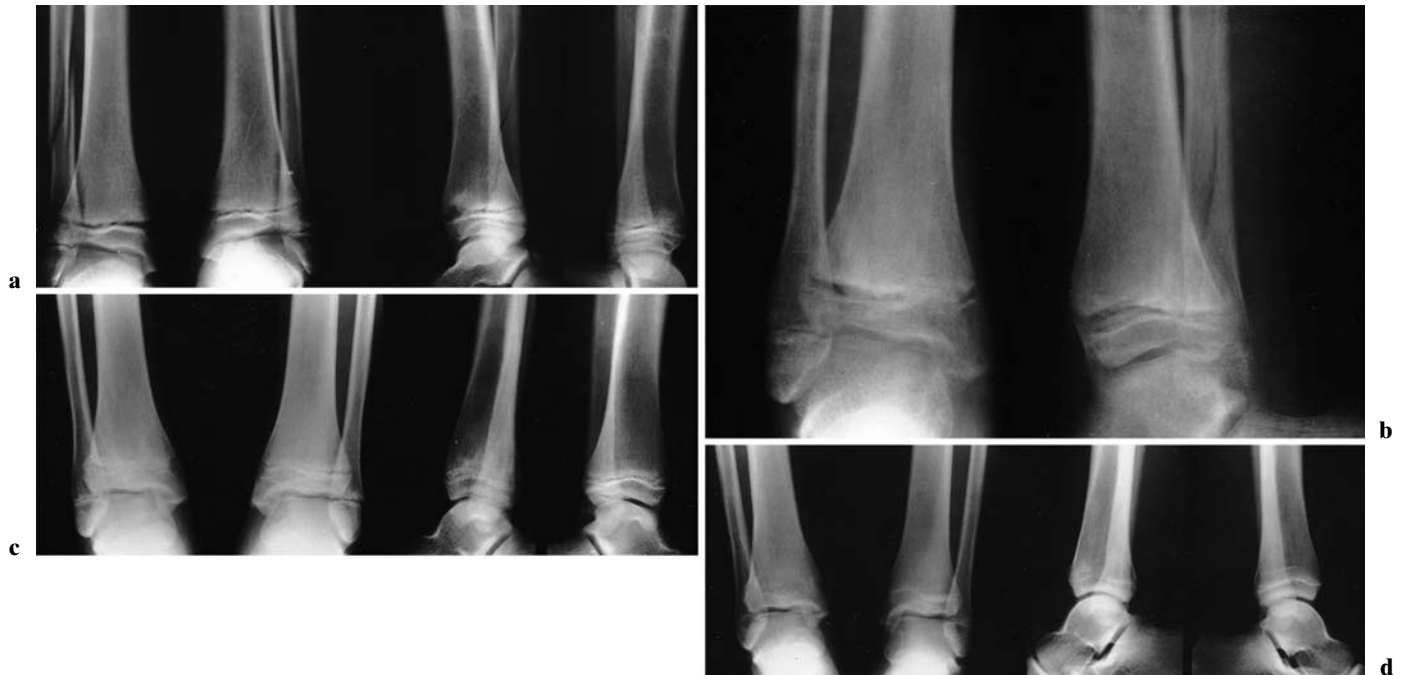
a Rotational injury of the right distal tibial physis in a 13-year-old boy accompanied by a spiral fracture of the distal third of the fibula, seen on comparative radiographs in frontal and lateral views. The characteristic sign of “open fish mouth” is seen on the lateral view but not on the normal one. b After
